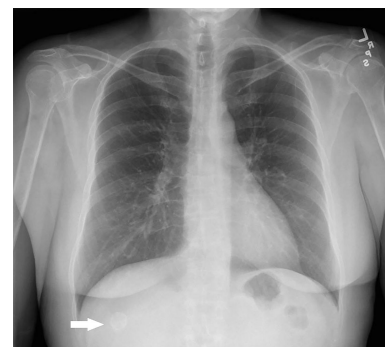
Frontal radiograph of the chest. The arrow shows a round, calcified lesion over the region of the right liver, corresponding to the calcified hydatid cyst seen on CT.
